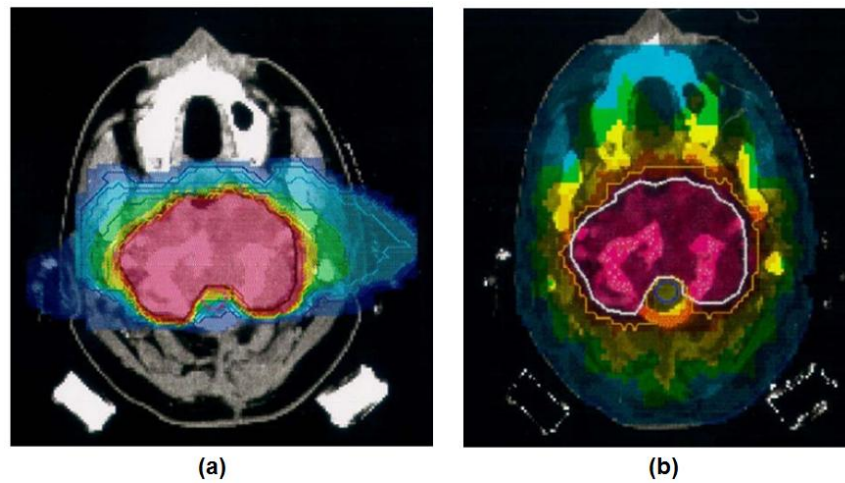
Comparison of treatment plans with 2 fields of carbon ion IMPT (Panel a) and with 9 fields of X-rays IMRT (Panel b). In both cases, a good conformity to the target volume is achieved, but in the IMPT plan the dose to the normal tissues is significantly lower [Amaldi 2005].
